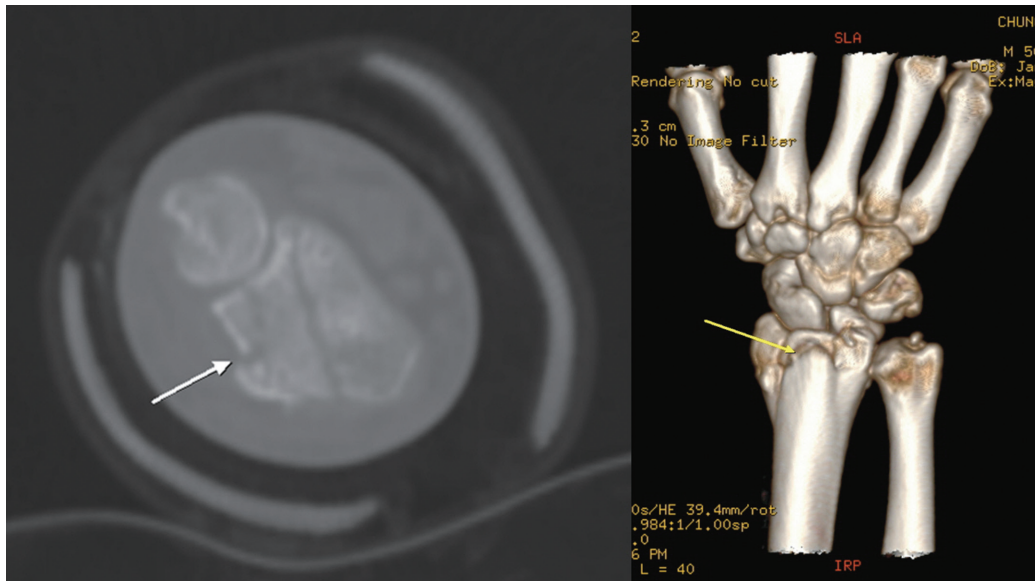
Axial and three-dimensional computed tomography images demonstrating a fracture of Lister's tubercle on the right side (arrows). A bony spur created a the gap between the fragment and the main radius part and might be the cause for tear of the tendon.
